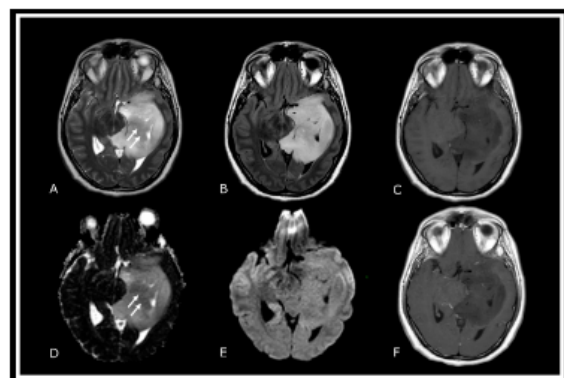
Example of magnetic resonance imaging used in brain tumor assessment and follow-up
